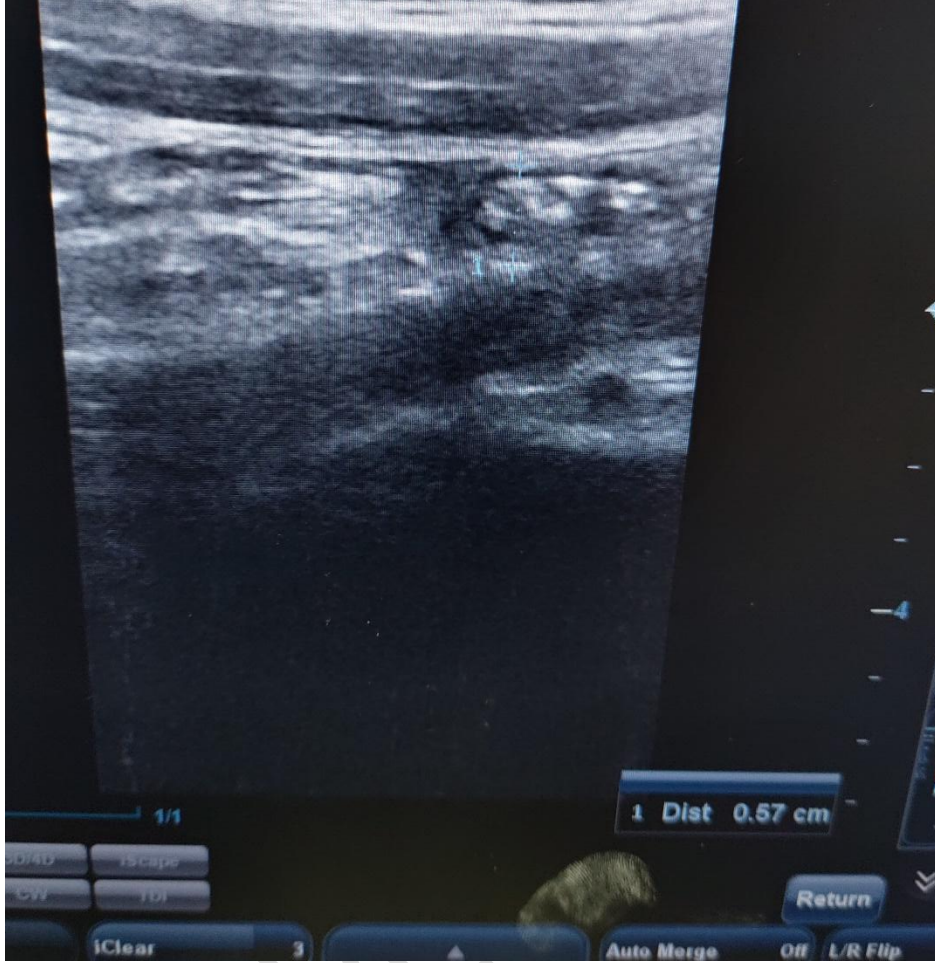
abdominal ultrasound scan revealing inflamed appendix
